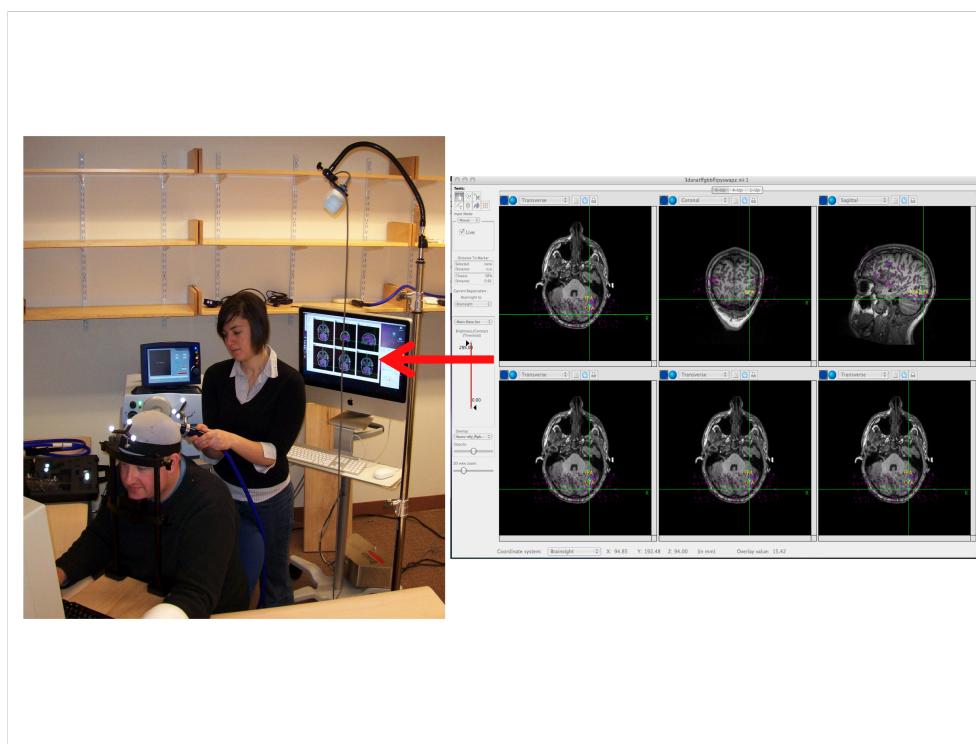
Where and how a specific cortical area can be targeted using a TMS coil (in this case TMS is being delivered over the right occipital face area). On the right are images from the Brainsight neuronavigation software used to identify the TMS target site. The subject's individual MRI scan is shown overlaid with the results of a face-selective functional localiser (faces minus objects). The Polaris camera (seen in the top right of the photo) identifies the precise location of the experimental subject and the TMS coil by sensing the location of the silver balls. This location information can be tracked online using the Brainsight software to ensure precise TMS coil placement over the targeted area throughout the experiment.
